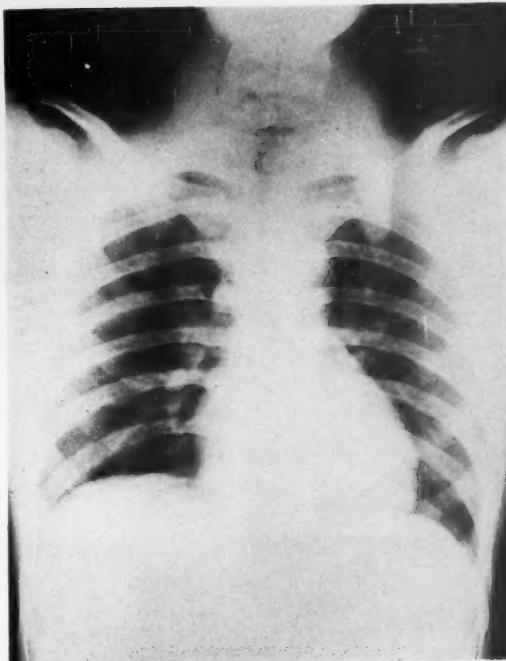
Roentgenogram of the chest in posteroanterior projection in Case 1 showing no evidence of pneumothorax. Note soft tissue bulging in neck.
